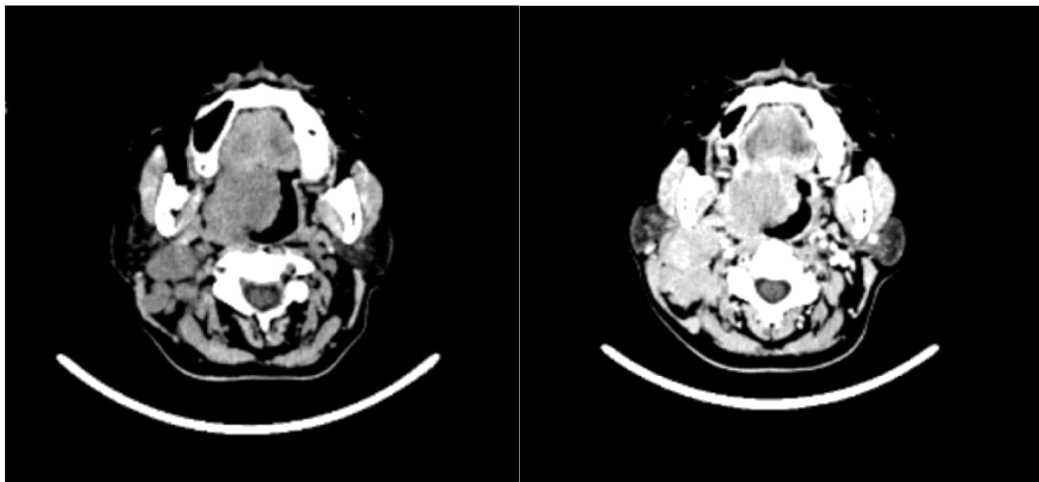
CT Scan of the midface showed compaction of the tonsils in lobulated shape, irregular edges, measuring 3.6x3.6x3.6 cm which extended to the oropharynx and had sharp contrast. Multiple enlarged lymph nodes were seen in the region colli, suprasternal, right and left para trachea with the largest diameter 3.8x6.0x6.9 cm, lobulated in shape pressing on the right parotid gland and right jugular vein.
